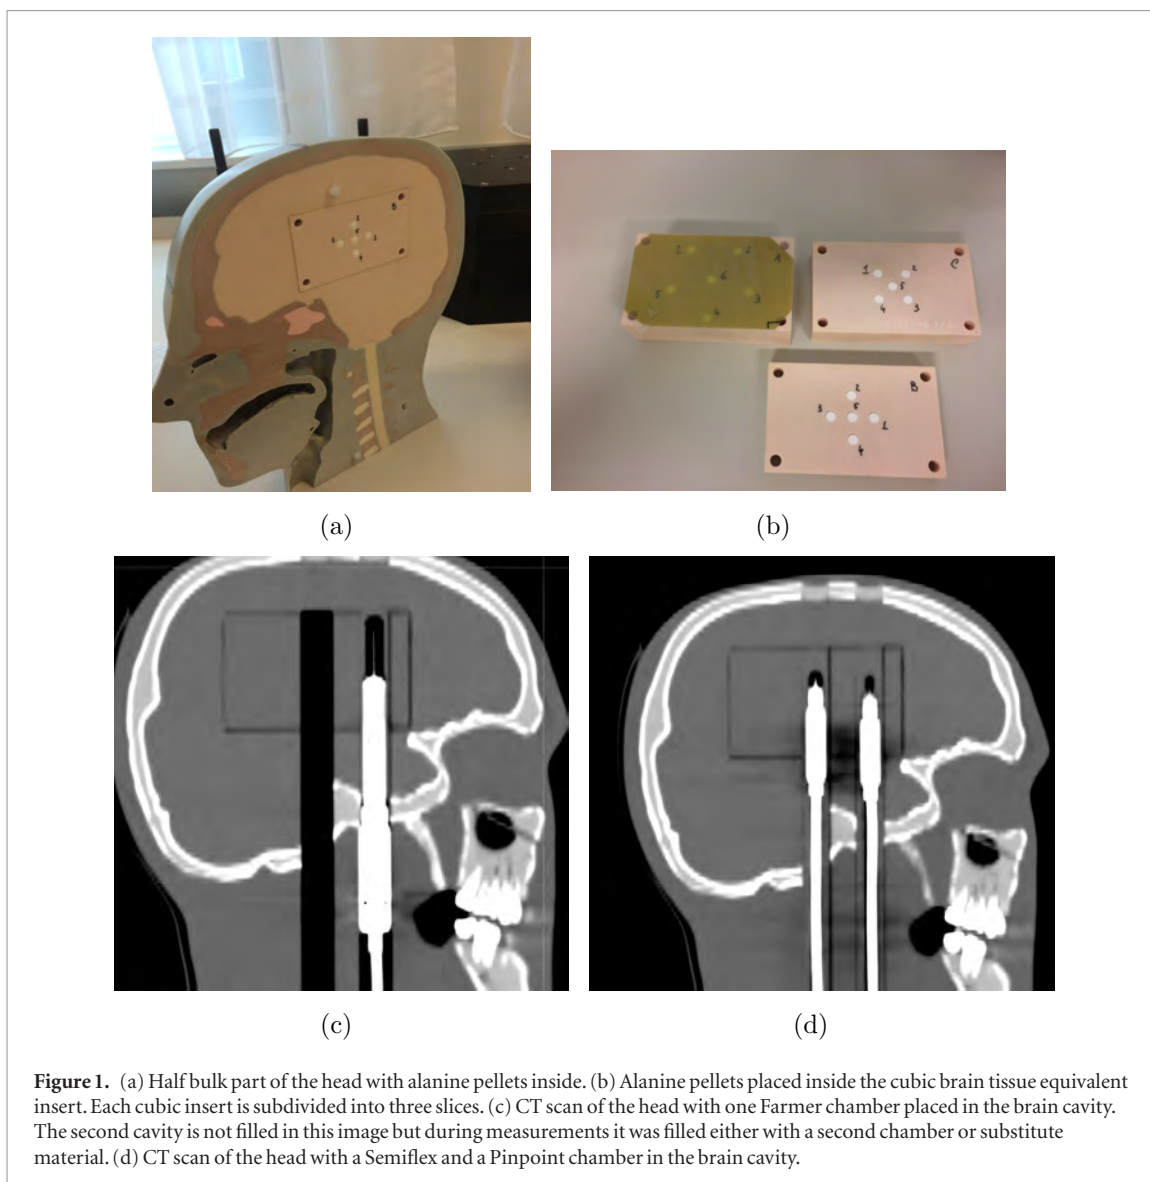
(a) Half bulk part of the head with alanine pellets inside. (b) Alanine pellets placed inside the cubic brain tissue equivalent insert. Each cubic insert is subdivided into three slices. (c) CT scan of the head with one Farmer chamber placed in the brain cavity. The second cavity is not filled in this image but during measurements it was filled either with a second chamber or substitute material. (d) CT scan of the head with a Semiflex and a Pinpoint chamber in the brain cavity.
